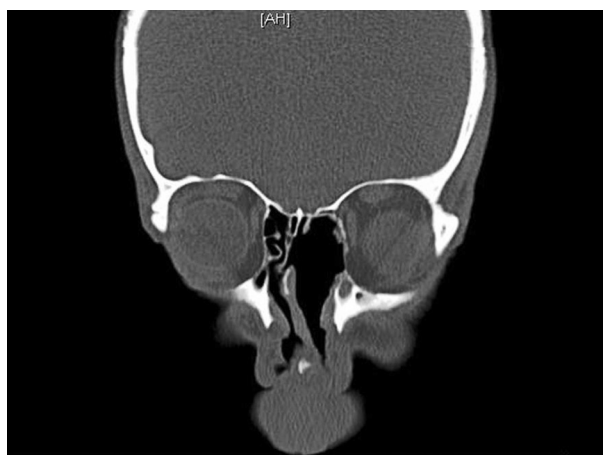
Six months after the operation, patient had no clinical complaints and paranasal CT showed no residual or recurrence.
